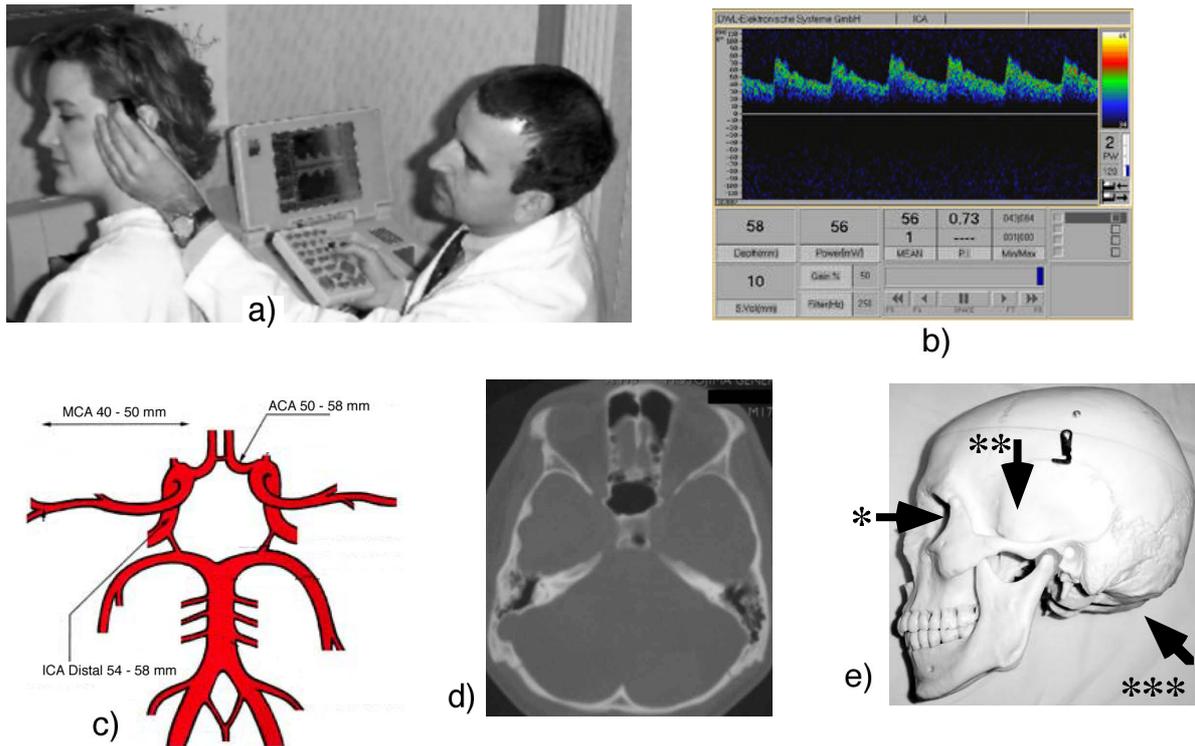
Transcranial Doppler Sonography (TCD)
